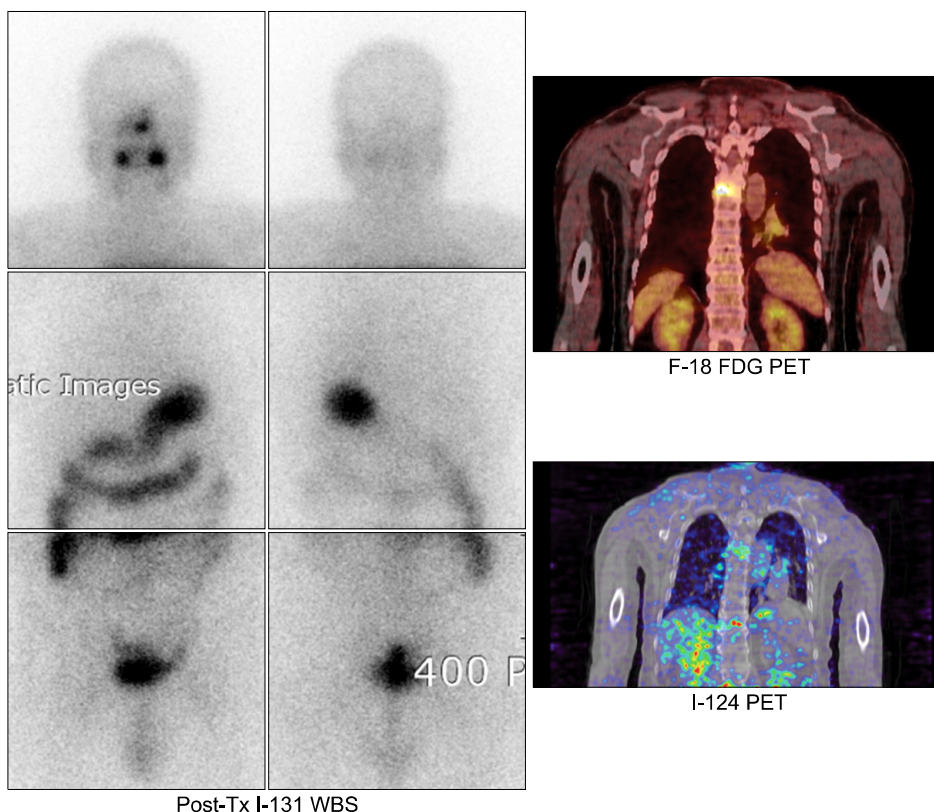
Iodine scan negative and FDG PET positive metastasis. A patient with differentiated thyroid cancer after the total thyroidectomy had a bone pain in the back. Iodine scan shows negative findings. On F-18 FDG PET scan, there is a focal hypermetabolic bone lesion on the contrary, suggesting malignant tumors. Iodine-124, a PET radiotracer of isotopes of iodine, demonstrate the faint iodine uptake on PET scans. This discrepancy between the I-131 scan and I-124 PET may be caused by the difference of the resolution of the instruments. This patient underwent the following high dose radioiodine treatment with improvement of bone pain.
